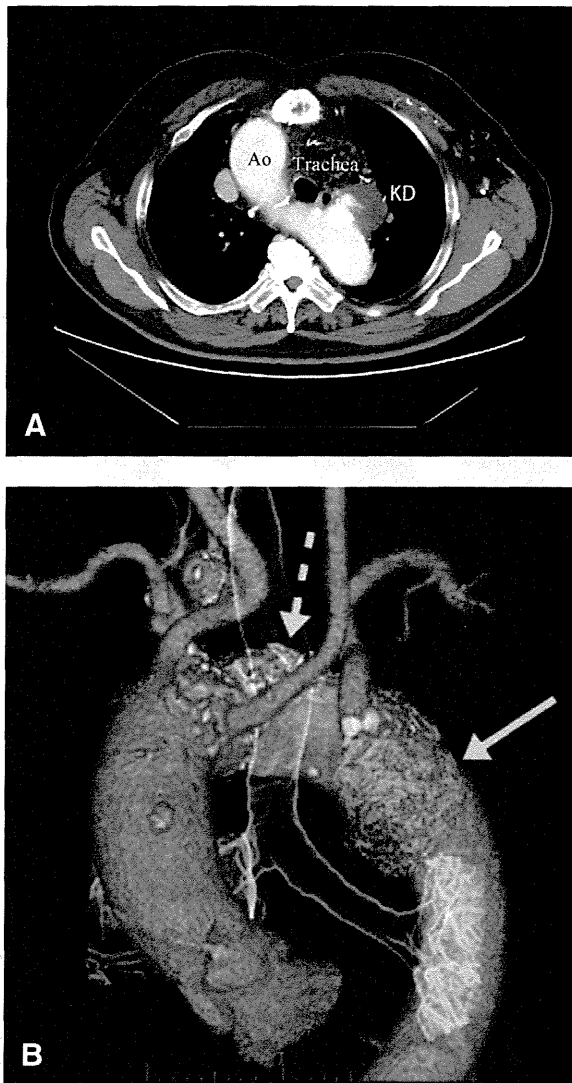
A, Preoperative computed tomography scan shows the right aortic arch (Ao) connected to the left descending aorta. The trachea overrides the aortic arch. KD, Kommerell diverticulum. B, Two aneurysms are shown as blue-colored areas: a 6.5-cm aneurysmal Kommerell diverticulum (solid arrow), and a 4.0-cm saccular-type aneurysm (dotted arrow; not enhanced because of thromboembolism).
